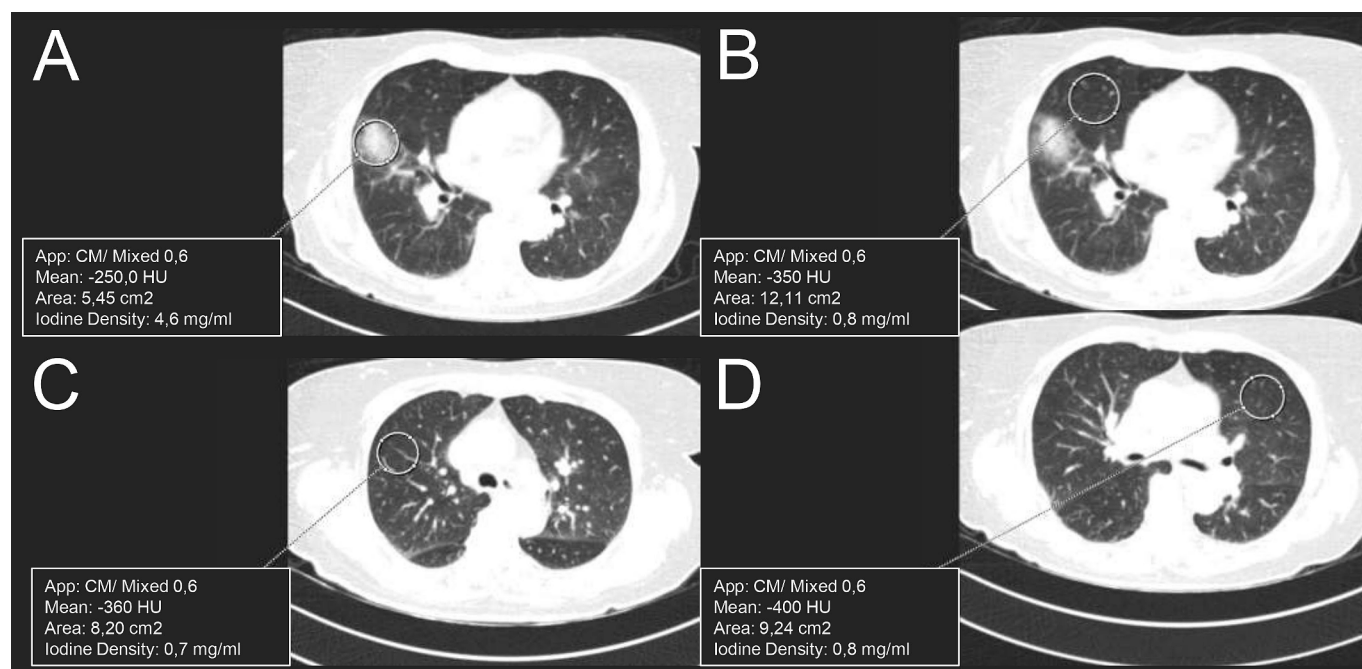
Iodine measurements within the lung injury and in normal parenchyma. (A–D) Non-contrast dual-energy CT in a 66-year-old male patient who had just undergone BPA and presented hemoptysis. (A) Measurement of iodine concentration within the lung injury (red circle). (B) Measurement of iodine concentration in the normal lung parenchyma immediately adjacent to the lung injury (red circle). (C) Measurement of iodine concentration in normal lung parenchyma in the same lobe of the lung injury (red circle). (D) Measurement of iodine concentration in normal lung parenchyma in the lung contralateral to the lung injury (red circle).
